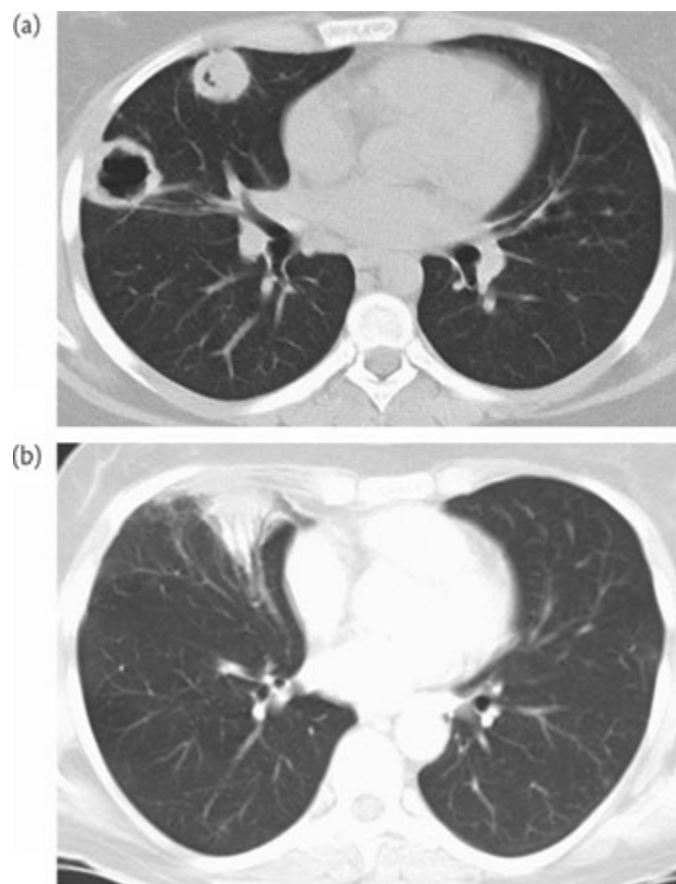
GPA most often presents radiologically. CT scans may reveal one or more nodules, which can cavitate (a), or localized (b) or diffuse infiltrates.
